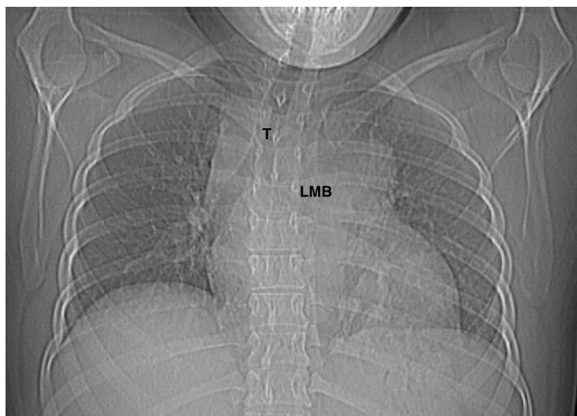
Chest X-Ray performed on day 0 revealing tracheal compression and partial obstruction of the left main bronchus.
